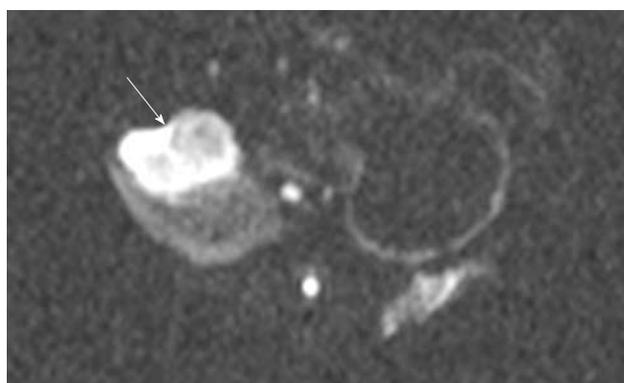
Single shot spin-echo planar diffusion weighted MRI ($b = 500 \text{ s/mm}^2$) showing pancreatic tumor (arrow) in axial view.
